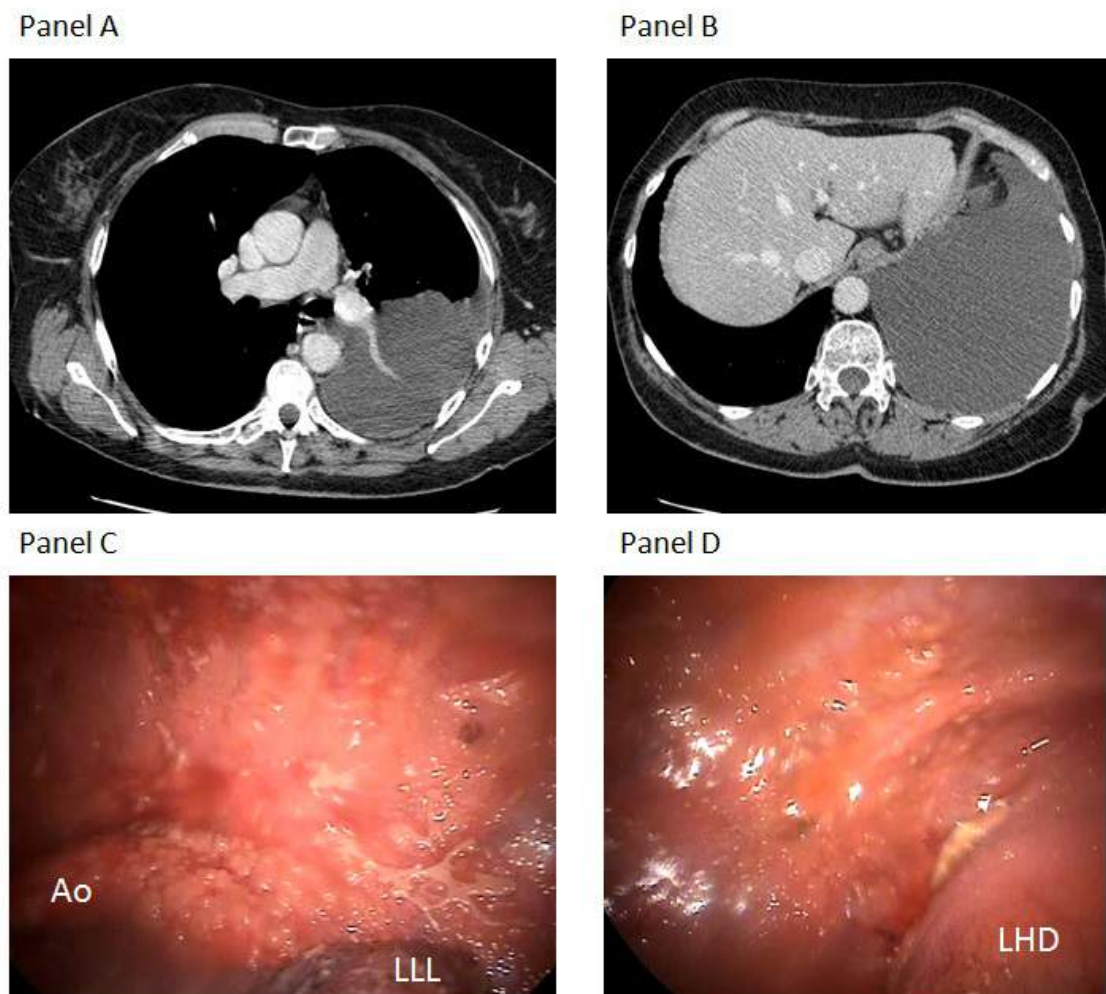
Axial contrast-enhanced CT images of a patient with Malignant Pleural Mesothelioma demonstrating a large left sided pleural effusion but little in the way of pleural thickening or nodularity (Panels A and B). Thoracoscopic findings in the same patient (Panels C and D) demonstrate diffuse nodular pleural tumour affecting the costal pleura, aorta (Ao), left lower lobe (LLL) and left hemidiaphragm (LHD) despite lack of obvious tumour at CT imaging. Reproduced with permission. (84)
